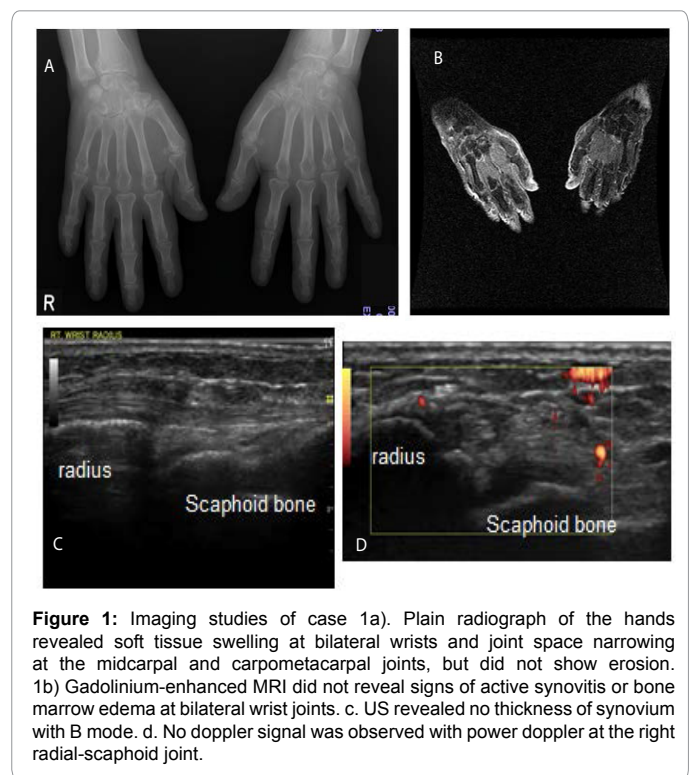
Imaging studies of case 1a). Plain radiograph of the hands revealed soft tissue swelling at bilateral wrists and joint space narrowing at the midcarpal and carpometacarpal joints, but did not show erosion. 1b) Gadolinium-enhanced MRI did not reveal signs of active synovitis or bone marrow edema at bilateral wrist joints. c. US revealed no thickness of synovium with B mode. d. No doppler signal was observed with power doppler at the right radial-scaphoid joint.
